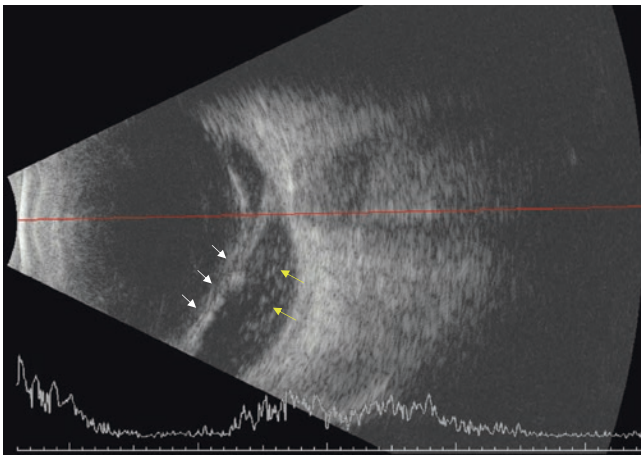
Ophthalmic B-scan ultrasonography shows an exudative retinal detachment (white arrows) with hyperreflective crystalline deposits or exudates (yellow arrows)
